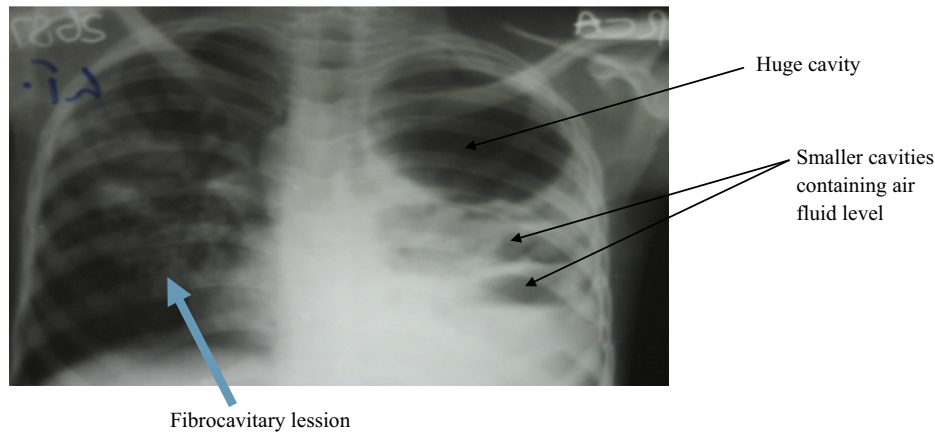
Chest X-ray of a 15 year old boy diagnosed of Pulmonary TB.
